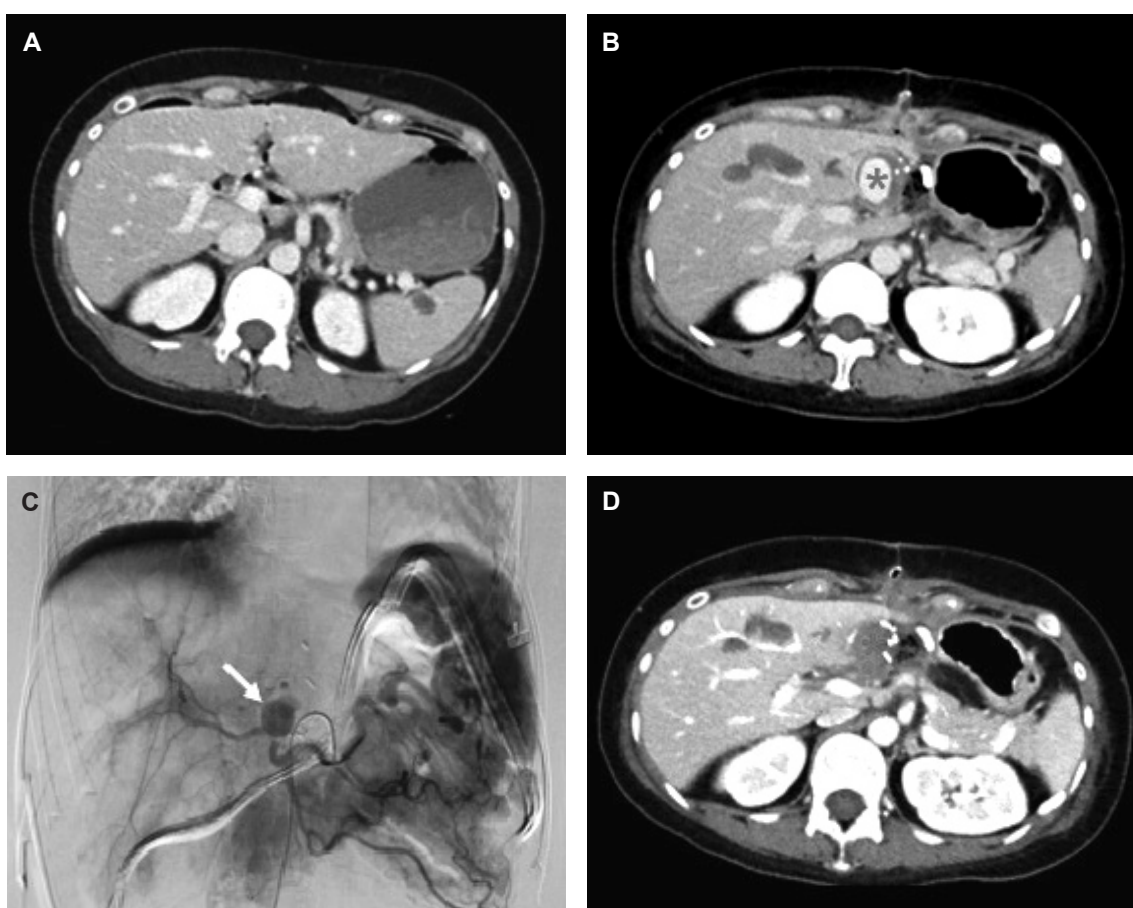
(A) The computed tomography of abdomen at emergent department on Day 1 of hospitalization revealed normal hepatic vessel structure. (B) Sequential abdominal CT identified a pseudoaneurysm (asterisk) up to 2.1 cm near hepatectomy resection margin on post-hepatectomy Day 7. (C) Trans-arterial embolization for the pseudoaneurysm (arrow) from left hepatic artery branch on the same day. (D) Follow-up computed tomography angiography of abdomen revealed a thrombosed pseudoaneurysm without obvious residual filling (asterisk) on post TAE Day 6.
